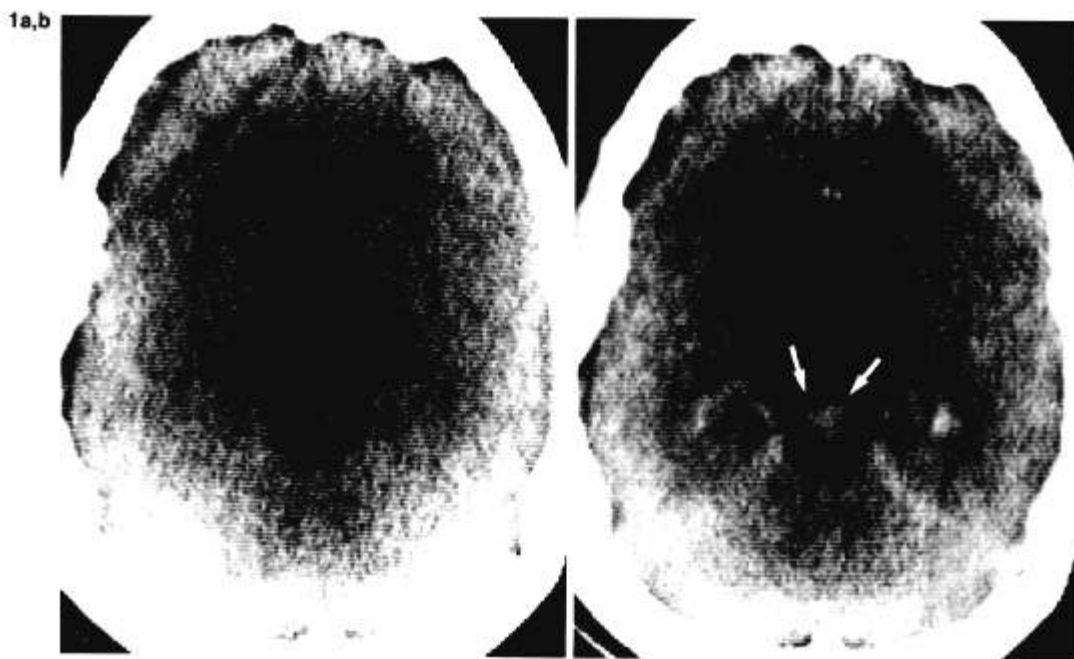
a: Plain CT is normal. b: Postcontrast CT shows enhancement in the midbrain (arrows). Patient had acute attack of meningoencephalitis characterized by lethargy, diplopia, truncal ataxia, and dysarthria.
